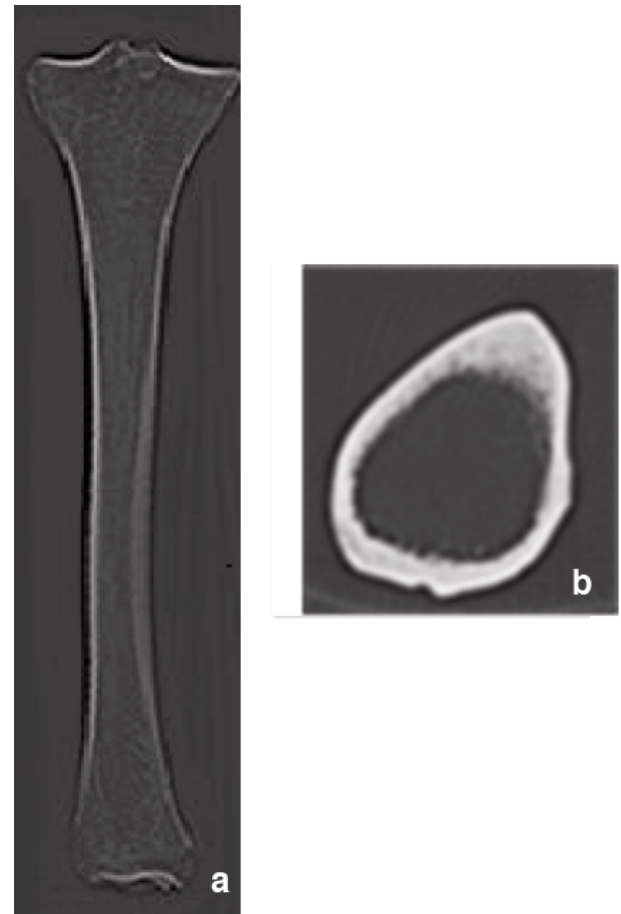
CT images of one of the tibia with marks (a), which include a cross section of the bone at the level of nutrition foramen (b). In Fig. 7a, it is evident that no periostitis exists, whereas in figure 7b no endosteal bone growth is observable.
